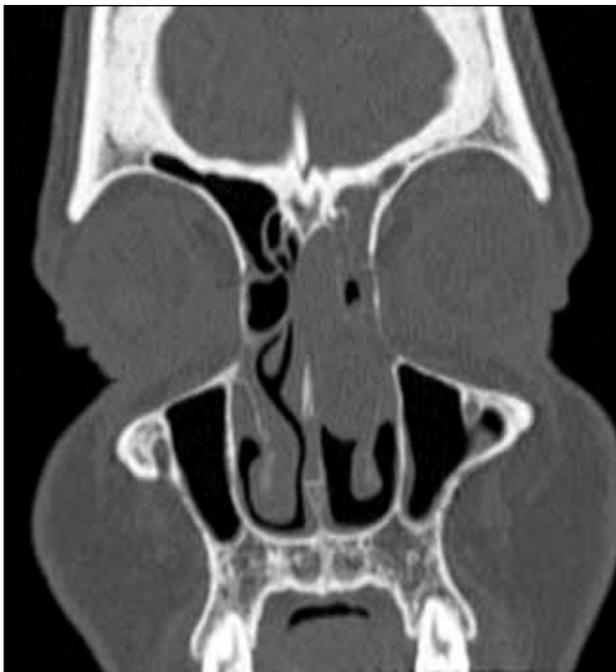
CT scan of the paranasal sinuses displaying opacification of the left ethmoid sinus
